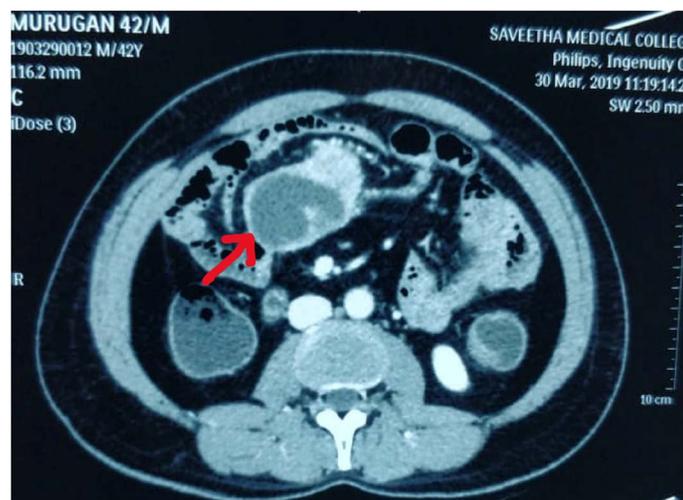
Shows the site of the small intestine GIST on contrast enhanced CT of the abdomen and pelvis (Red arrow).
